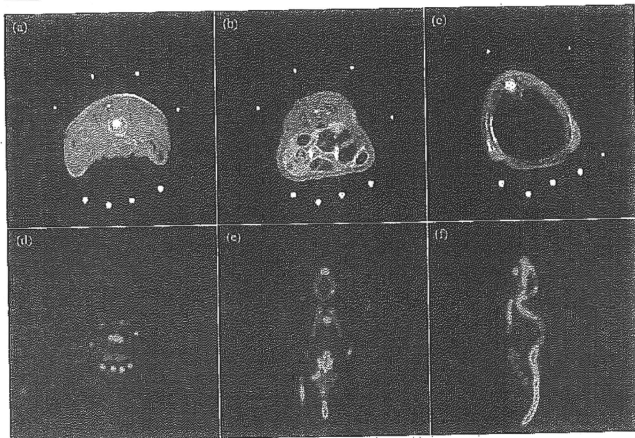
(a)–(c) MR and (d)–(f) PET images. In the MR images, the positions (a) and (b) were within the range covered by the lower body fixture, and (c) outside the fixture. On the PET images, the planes were (d) transverse, (e) horizontal and (f) sagittal. No artifact was observed due to the proposed fixtures, and all fiducial markers were detectable in (a), (b) and (d).
